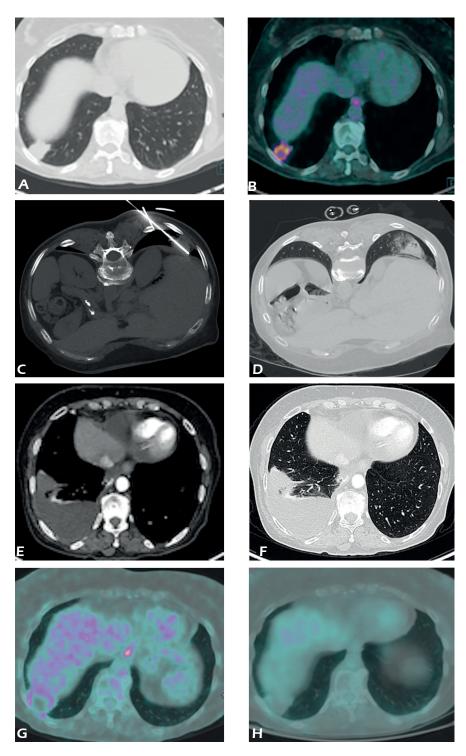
58-year-old woman with single lung metastasis from parotid gland cancer. CT image in axial plane (A) shows a 32 × 24 mm lung parenchymal nodule in right lower lobe, with high FDG uptake on PET-CT (B). Pulmonary ablation of the lesion using a 15G jet-tip electrode, after creating iatrogenic pneumothorax to displace lung far away from diaphragm, was performed (C). Immediate post-procedural unenhanced CT-scan shows peripheral lesion ground-glass opacity due to edema, inflammation and mild hemorrhage (D). 1-month contrast-enhanced CT axial images (E-F) show diffuse hypoattenuating necrotic nodule with intralesional air bubble and peripheral mild, thin and smooth enhancement and pleural omolateral suffusion, as sign of pleural reaction. PET-CT exam performed 3 months after treatment (G) shows photopenic central area with mild peripheral hypermetabolic component, due to inflammatory reaction, without residual vital tumor, as confirmed by complete absence in FDG uptake at 6-month PET-CT scan follow-up (H) (metabolic complete response).
